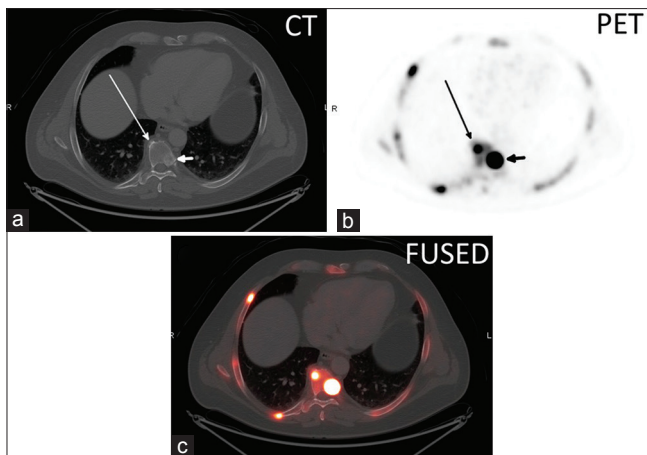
(a) Axial CT, (b) axial ^{18}F NaF PET, and (c) axial fused PET/CT image of thoracic spine degenerative disc osteophyte (long arrow) with a SUV_{max} of 29.6 and an adjacent sclerotic vertebral body metastasis (short arrow) with a SUV_{max} of 95.6
